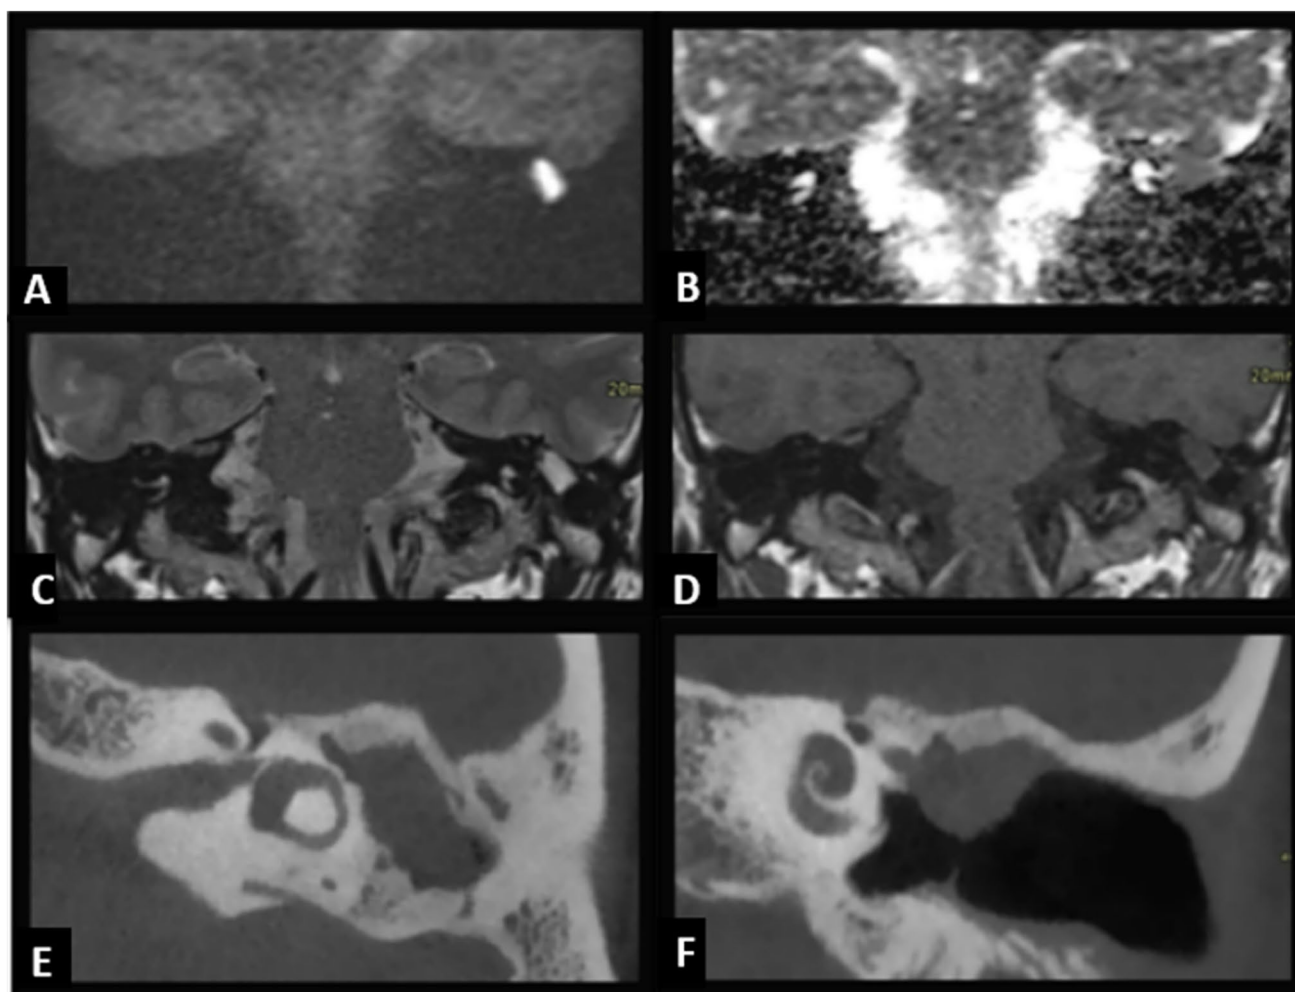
Patient with prior canal wall up tympanoplasty for cholesteatoma, presenting now with clinical suspicion at otoscopy of a recurrent cholesteatoma. Coronal non-EPI DWI with $b=1000$ s/mm² A, ADC map B, T2-weighted image and T1-weighted image through the middle ear, slice thickness of 2 mm C and D. The lesion shows a high intensity on non-EPI DWI with a clear signal drop on ADC map. It displays an intermediate intensity on T2WI and shows a low
